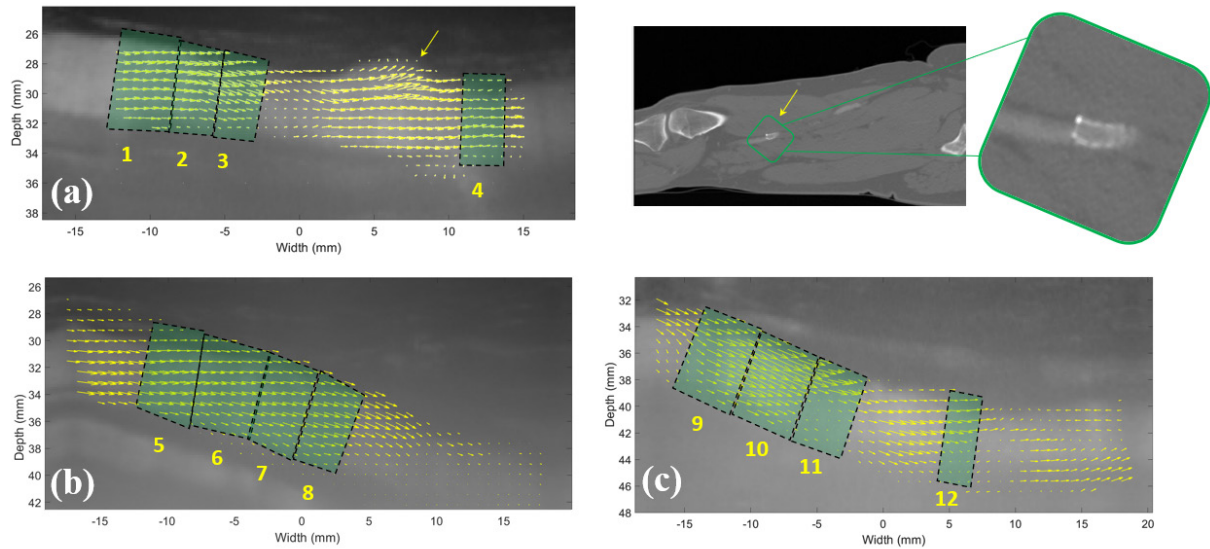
The shape of the time-averaged vector fields (output of echoPIV) in the superficial femoral artery (SFA), stented with a Biomimic 3D helical stent: (a) straight leg, upstream of the stent, (b) straight leg, middle of the stent, (c) flexed leg, middle of the stent. On the right side of (a), a CT scan of the stent shows that the inlet of the stent had malapposition, causing extra flow patterns to form as shown by the arrow in (a). The twelve regions analyzed for vector complexity and skewedness are shown as masks over the images. The brighter region of each image is the strong average signal due to the contrast bubbles, clearly showing the boundaries of the SFA.
